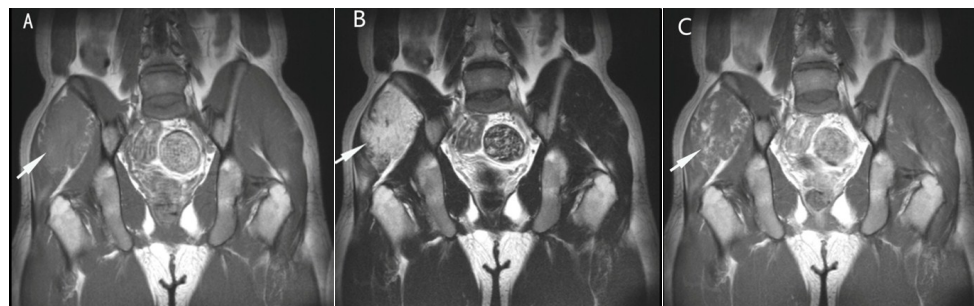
MR findings of the lesion. A. T1 weight MR presented slight hyperintensity. B. T2 weight MR exhibited asymmetrical hyperintensity and small foliated hypointensity. C. Enhanced MRI scan showed uneven and moderate reinforcement of the lesion.
